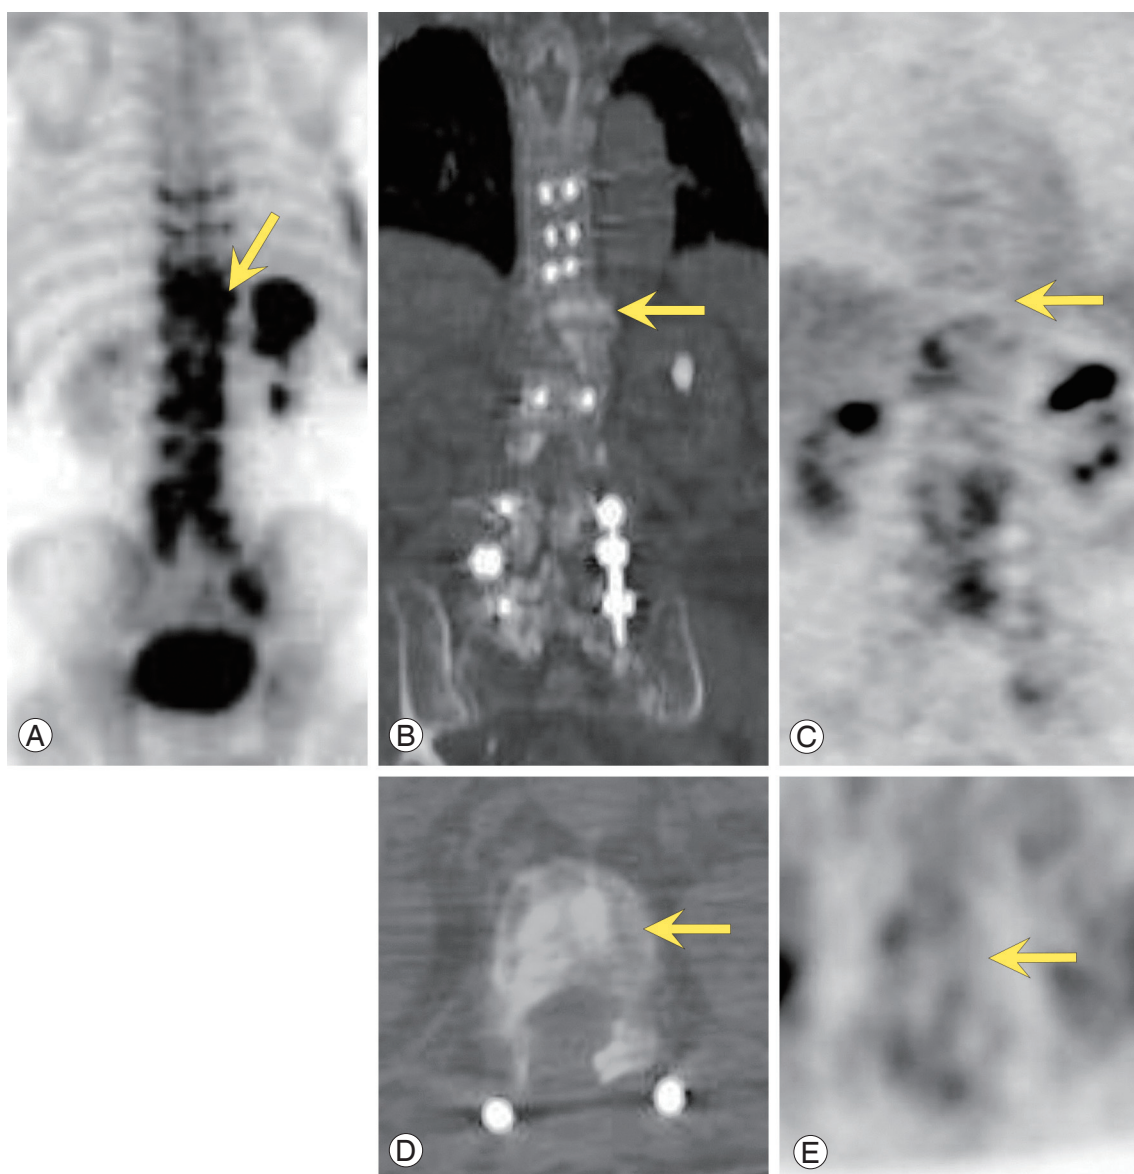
Bone scan (A), CT, (B, D) and FDG PET (C, E) images of a 77-year-old man with prostate carcinoma. Note the focal intense uptake of osteoblastic spine metastases (vertebral body of T11) on the bone scan only but not on the PET images (arrows). Axial and coronal CT images show osteosclerotic changes in the vertebral body (B, D) and no focal intense uptake on the PET images (C, E). CT, computed tomography; FDG, fluorodeoxyglucose; PET, positron emission tomography.
